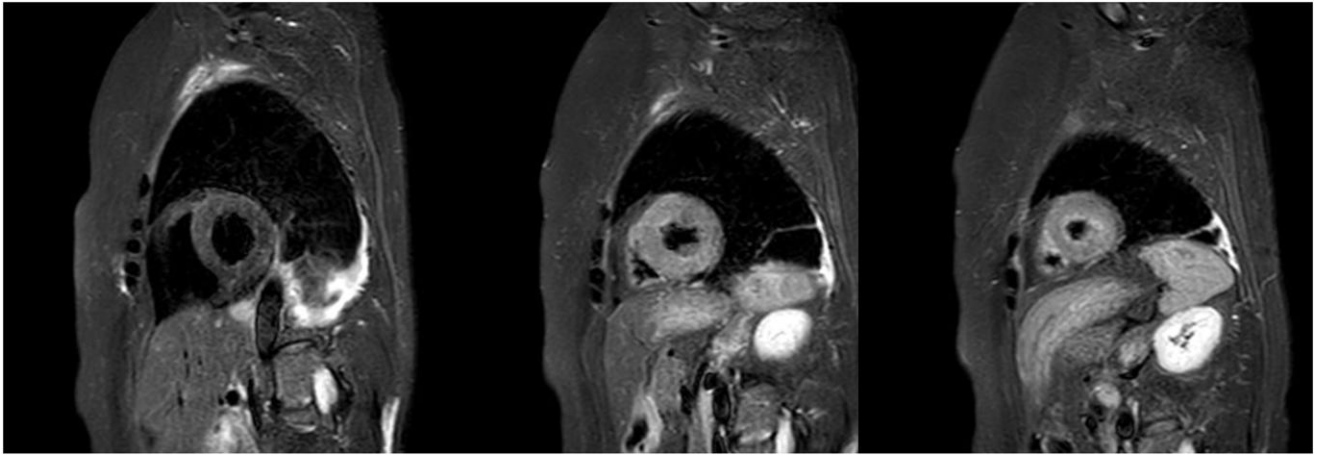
MRI T2 stir sequences showing hyperintensity of signal at midventricular and apical segments.
